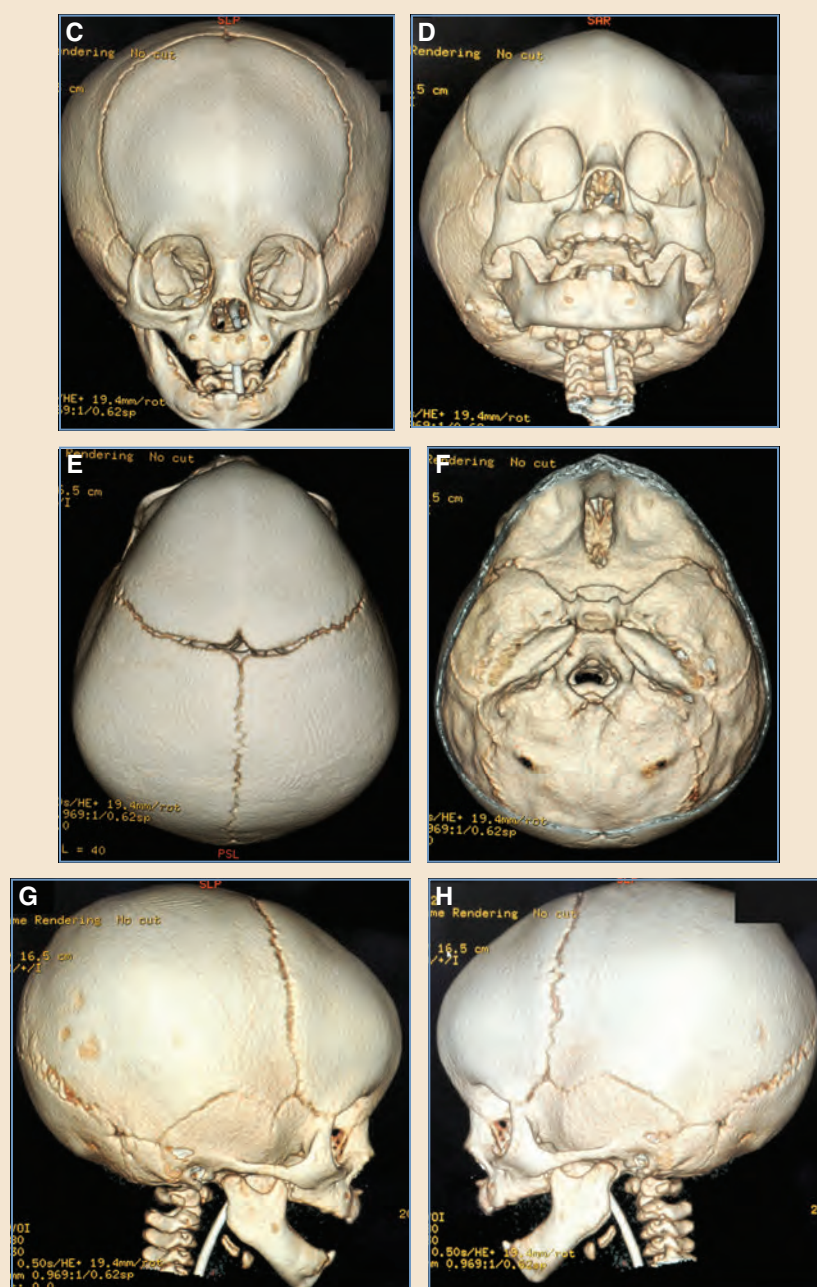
cont'd C-H, Preoperative CT images.
